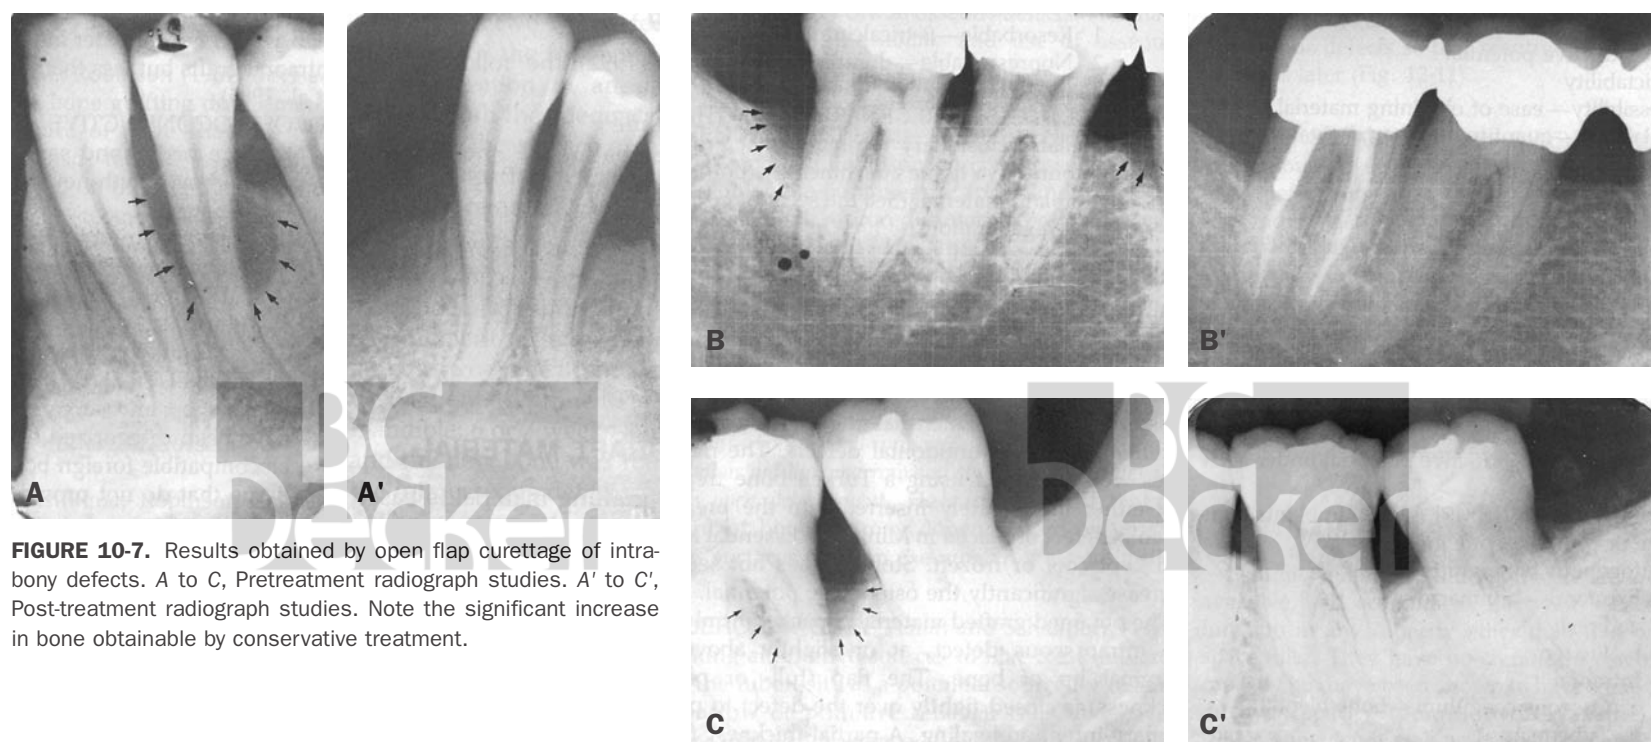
Results obtained by open flap curettage of intra-bony defects. A to C, Pretreatment radiograph studies. A' to C', Post-treatment radiograph studies. Note the significant increase in bone obtainable by conservative treatment.
